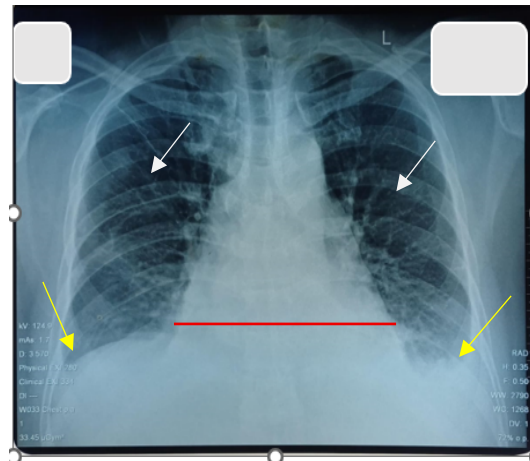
Patient's Chest X-ray Showed bronchovascular cranialization (white arrow), bilateral Pleural Effusion (yellow arrow) with Significant Enlargement in The Cardiac Shape (red line).
